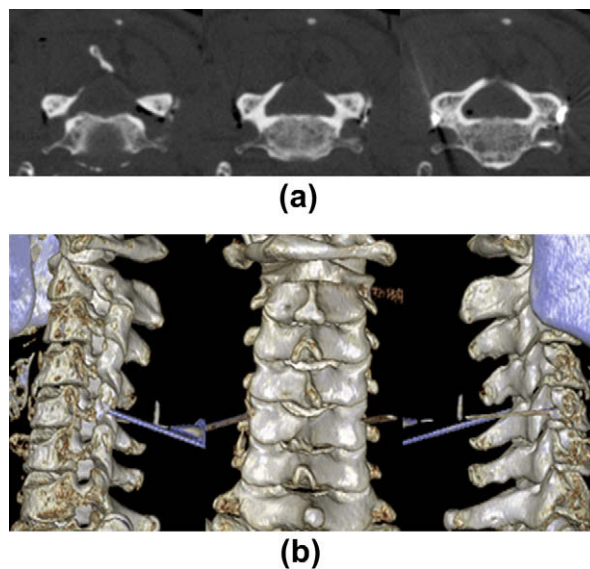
Sequential axial CT images (a) show needle tips at the target points for both-sided C5 medial branch neurotomies, and typical localized air and contrast medium spread reaching the location of the cervical medial branch. The exact placement of the needle tips was again verified by three-dimensional rendered CT images (b).
